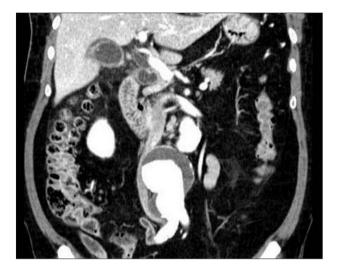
The fusiform aneurysm had a dumbell shape. This computed tomography image also shows gall bladder wall thickening consistent with acute cholecystitis.
